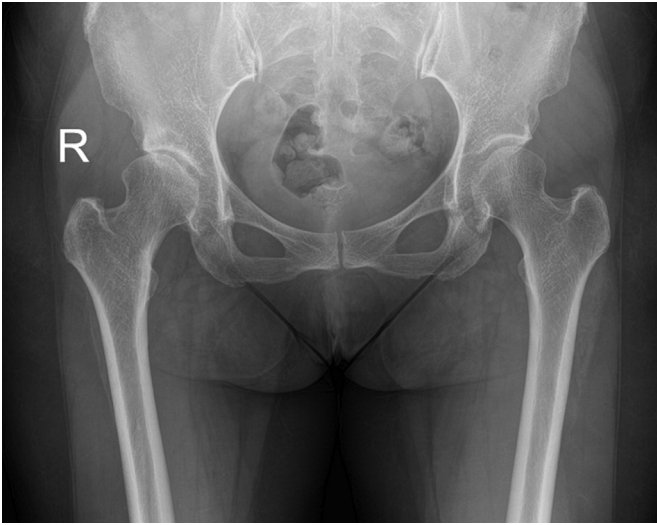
Preoperative radiograph of the patient, both hip AP.
